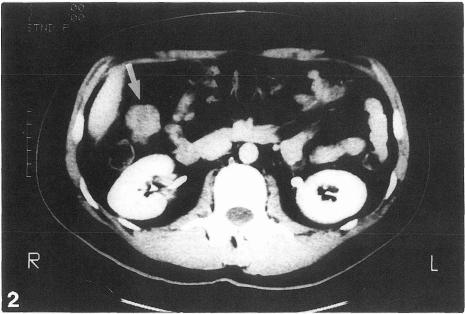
Case 1: One of the extrahepatic abdominal tumors (indicated by arrow) was recognized on the preoperative CT, retrospectively.
